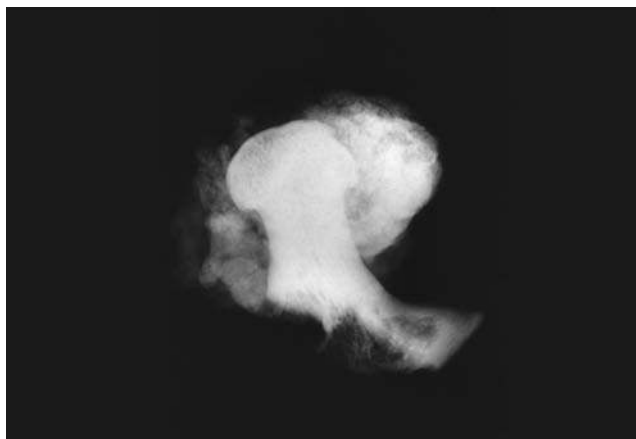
Plain film of synovial chondromatosis resulting in pressure erosion of the underlying bone.
